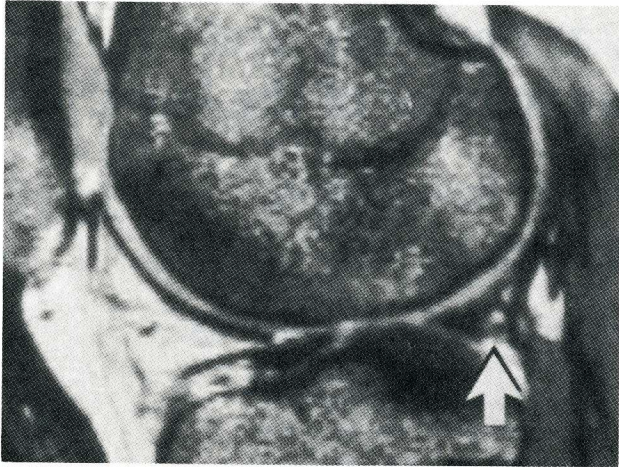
Three-dimensional gradient-recalled echo (repetition time, 40 ms; echo time, 14 ms; flip angle, 40°) sagittal magnetic resonance (MR) image of the knee (externally rotated approximately 20°) obtained in a man aged 36 years. The patient had a twisting sports injury and was complaining of persistent pain and swelling. He had a tear, diagnosed with arthroscopy, at the meniscocapsular junction (arrow). At initial examination with MR imaging, this tear was believed to be fluid in the meniscal recess. The MR images also showed low signal intensity in the anterior subcortical region of the femoral condyle. These appearances are believed to be due to bone bruising. (From Heron and Calvert [1]; with permission.)
